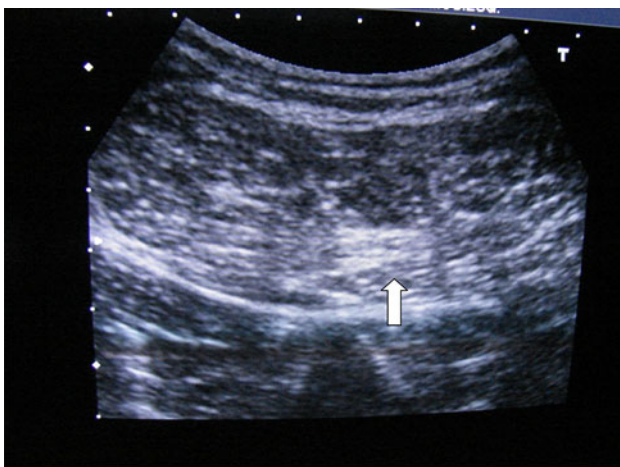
Ultrasound view of sciatic nerve (arrow)
